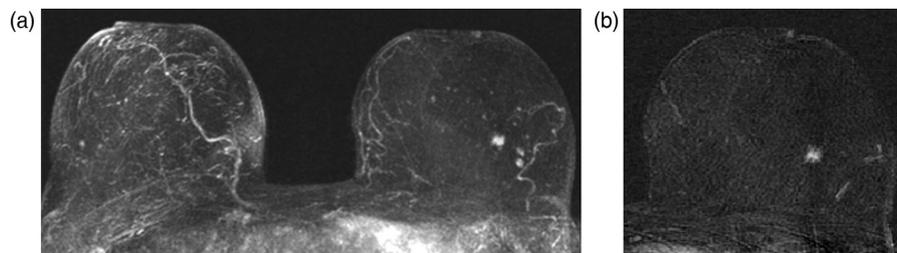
Tubular breast carcinoma. MRI of the breast. MIP technique (a) and the single slice subtraction image of the left breast (b) show an irregular mass with spiculated borders
